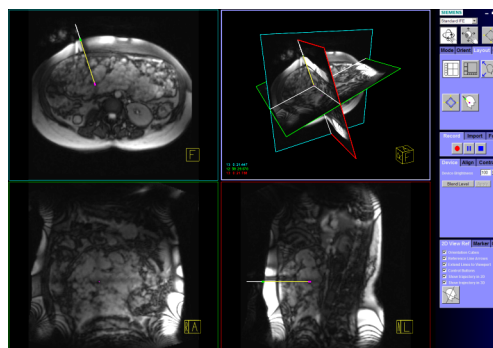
Needle placement under real-time MRI following automatic slice alignment. The slice orientations are visible in the 3D view (upper right) and by the orientation cubes (yellow boxes).
